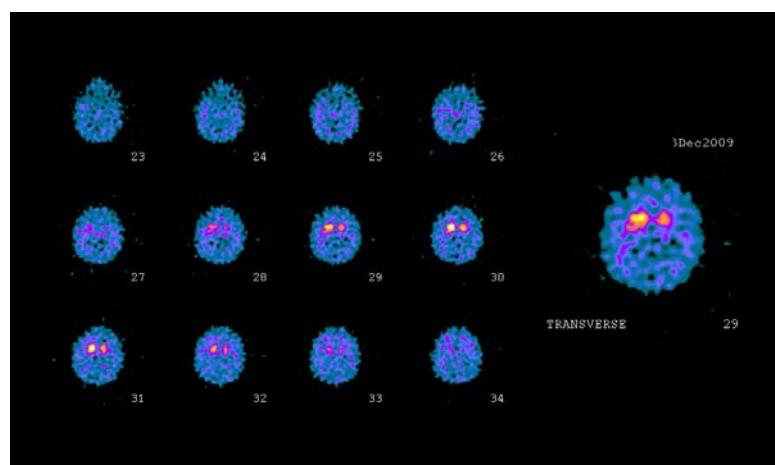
^{123}I -FP-CIT SPECT interpreted as moderate presinaptic dopaminergic deficit in patient with Parkinson's disease (clinical stage 2.0 H&Y)
